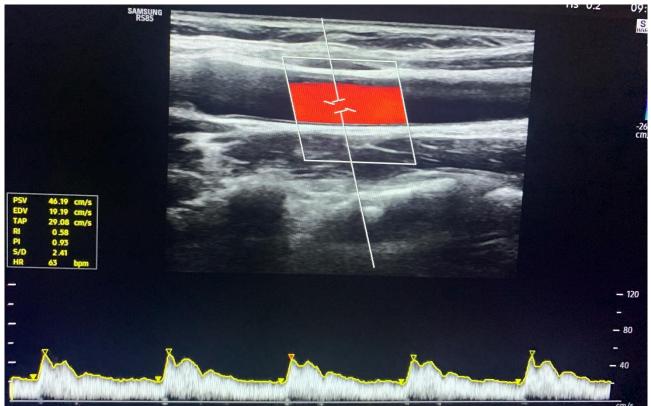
Internal carotid artery power doppler ultrasonography examination and spectral imaging
